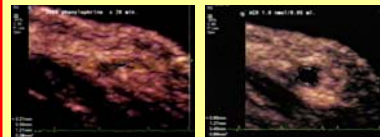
Ultrasound image of dorsal vein showing maximum dilation with acetylcholine, right panel, as compared to baseline pre-occlusion, left panel.
